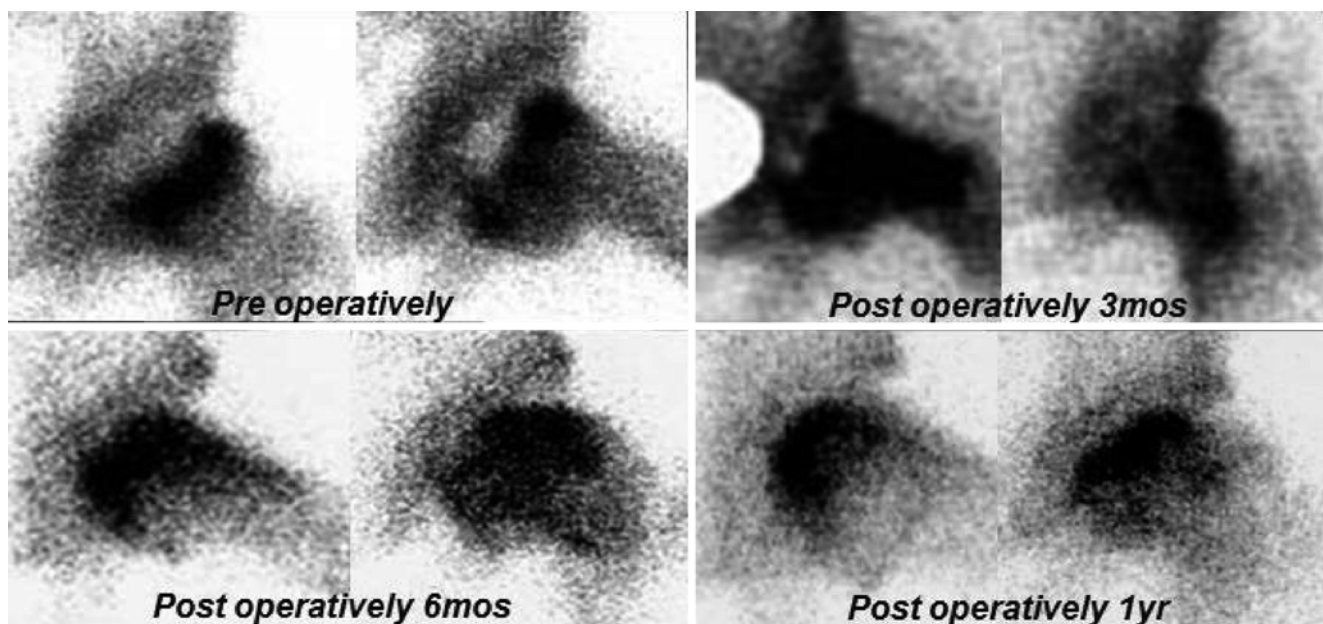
Serial pinhole bone scintigraphy after vessel-pedicle bone graft for osteonecrosis of the femoral head shows gradually increasing uptake in the femoral head
